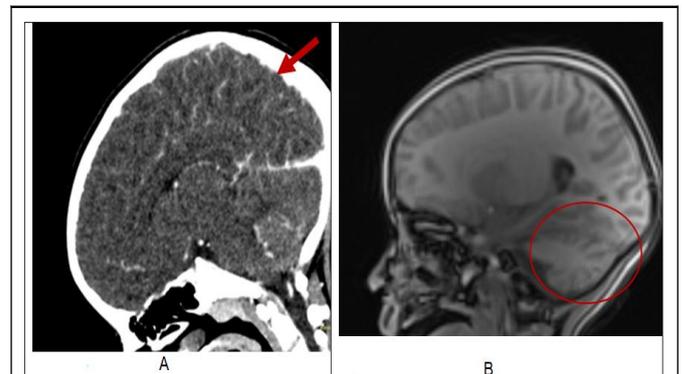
(A) Axial CT venogram showing a filling defect in the superior sagittal sinus (arrow), initially concerning for cerebral venous thrombosis; further evaluation confirmed this as a congenital variant, (B) Sagittal T2-weighted brain MRI demonstrating bilateral cerebellar hyperintensities with leptomeningeal enhancement, consistent with acute cerebellitis (circle shown).
